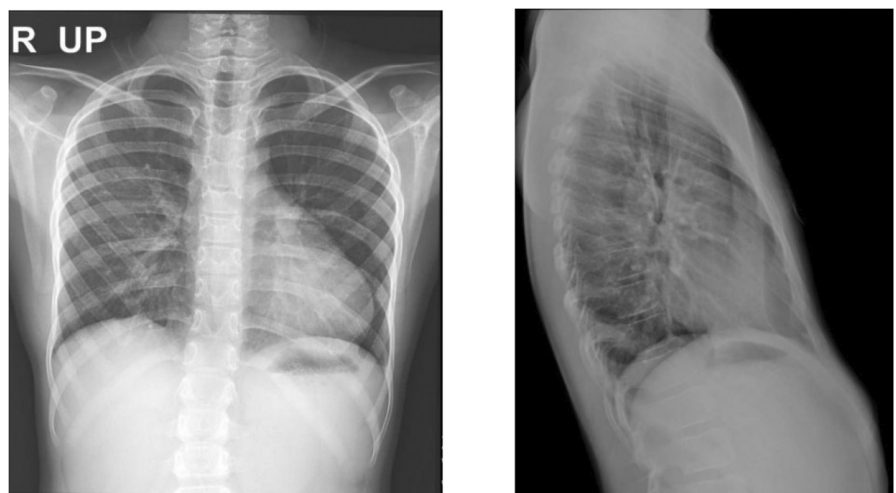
Preoperative posteroanterior (PA) and lateral chest X-ray views.
